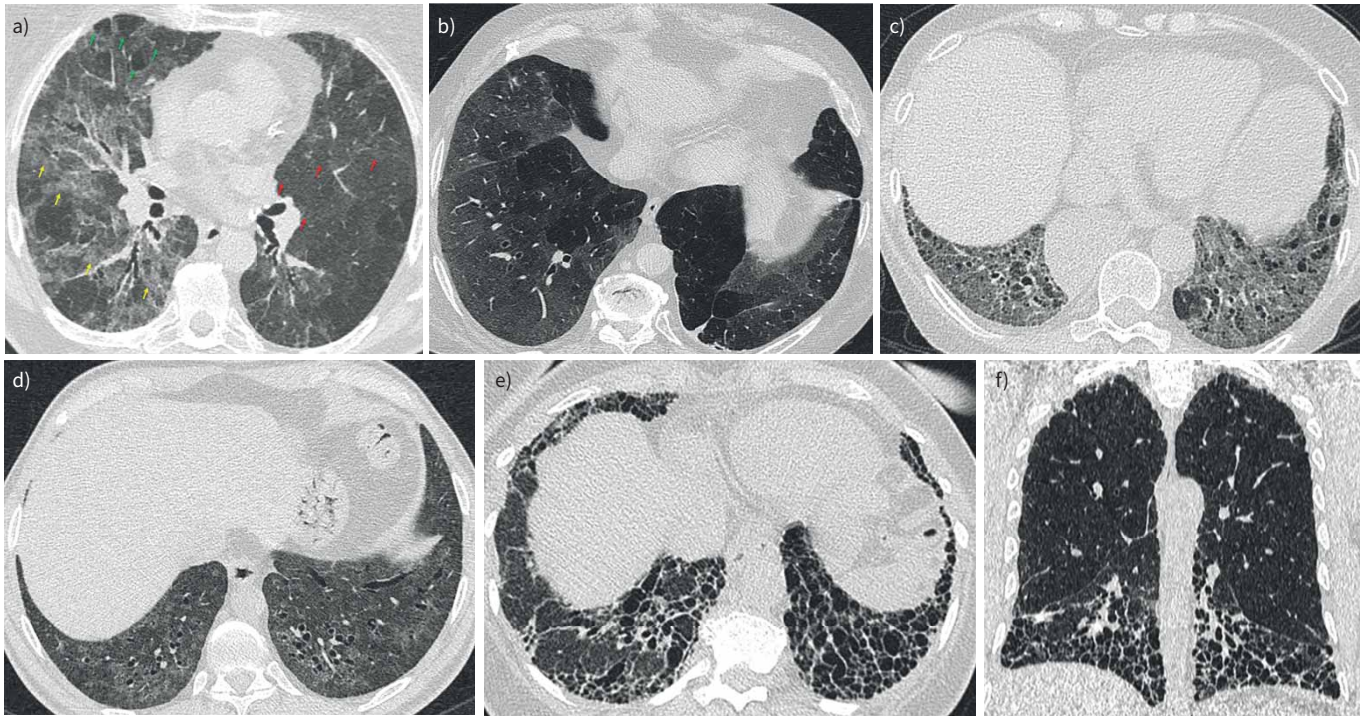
Single-slice axial and coronal high-resolution computed tomography (HRCT) images demonstrating different parenchymal patterns that may influence multidisciplinary assessment of unclassifiable interstitial lung disease. a) The three-density pattern is present when normal-density lung (red arrows), high-density ground-glass opacities (yellow arrows) and low-density areas due to small airways disease (green arrows) coexist. When signs of fibrosis are also present, this pattern is specific for fibrotic hypersensitivity pneumonitis. b) Diffuse ground-glass opacities in a patient with nonfibrotic nonspecific interstitial pneumonia (NSIP). The absence of traction bronchiectasis as well as the homogenous, amorphous quality of the ground-glass opacification suggests this pattern reflects a nonfibrotic, inflammatory infiltrate. c) Fine reticulation mimicking ground-glass opacities in a patient with idiopathic pulmonary fibrosis. In contrast to b), this pattern has a coarse quality caused by fine intralobular septal thickening. The presence of traction bronchiectasis confirms the presence of fibrosis. d) Fine reticulation mimicking ground-glass opacities in a patient with fibrotic NSIP. The reticular quality of this pattern is more subtle than in c), but the presence of severe traction bronchiectasis helps to classify it as fibrotic. e) and f) Axial and coronal HRCT images depicting basal subpleural honeycombing, traction bronchiectasis and coarse reticular opacities typical of usual interstitial pneumonia.
